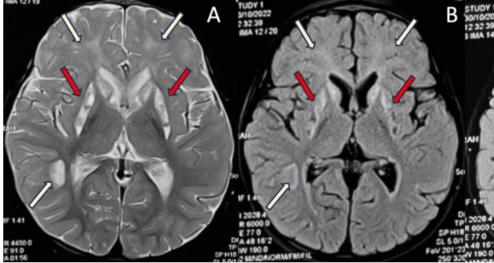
MRI brain T2 axial section and T2 FLAIR axial sections show hyperintensity and cavitation in bilateral frontal dominant periventricular and subcortical white matter, right parietal white matter(arrows in A,B & C) and basal ganglia(arrows in red in A & B). DWI shows diffusion restriction in bilateral basal ganglia(red arrows in D) and parietal cortical white matter(arrow in D) (Mixed pattern)
